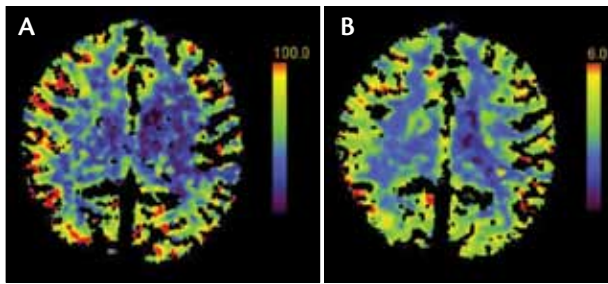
Axial CT scans. Note the cerebral blood flow image demonstrating decreased density in the left hemisphere (A). The cerebral blood volume in that same area does not show this density reduction, suggesting preservation of brain tissue (B).
